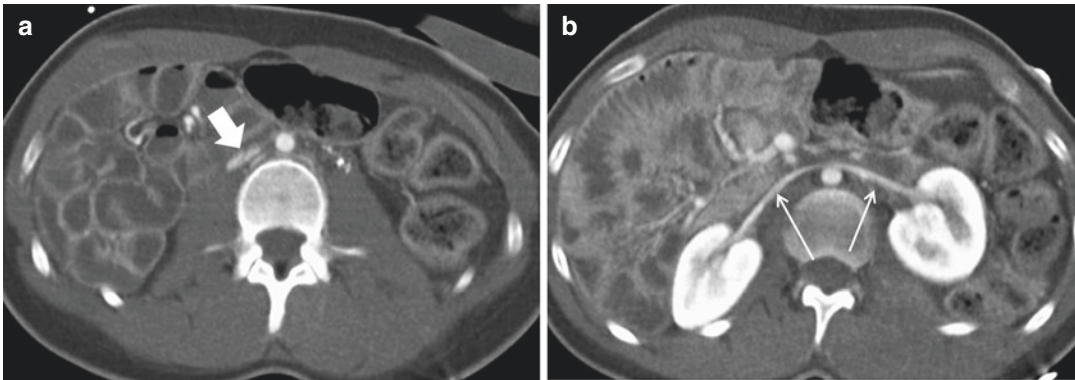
Axial CT contrast-enhanced image shows diffuse hypervascular thickening of small bowel loops, with mucosal feathering, features characteristic of shock
